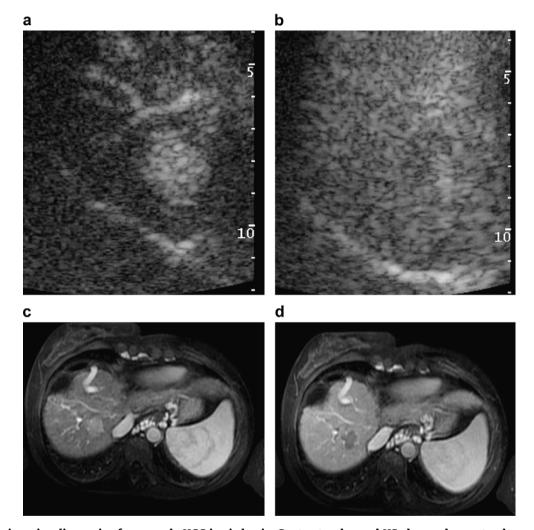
Non-invasive diagnosis of very-early HCC in cirrhosis. Contrast-enhanced US shows clear-cut enhancement in the arterial phase (a) with rapid wash-out in the portal venous phase (b) in a 2-cm nodule in cirrhosis. The same findings are observed on dynamic contrast-enhanced MR images obtained in the arterial phase (c) and the portal venous phase (d).
